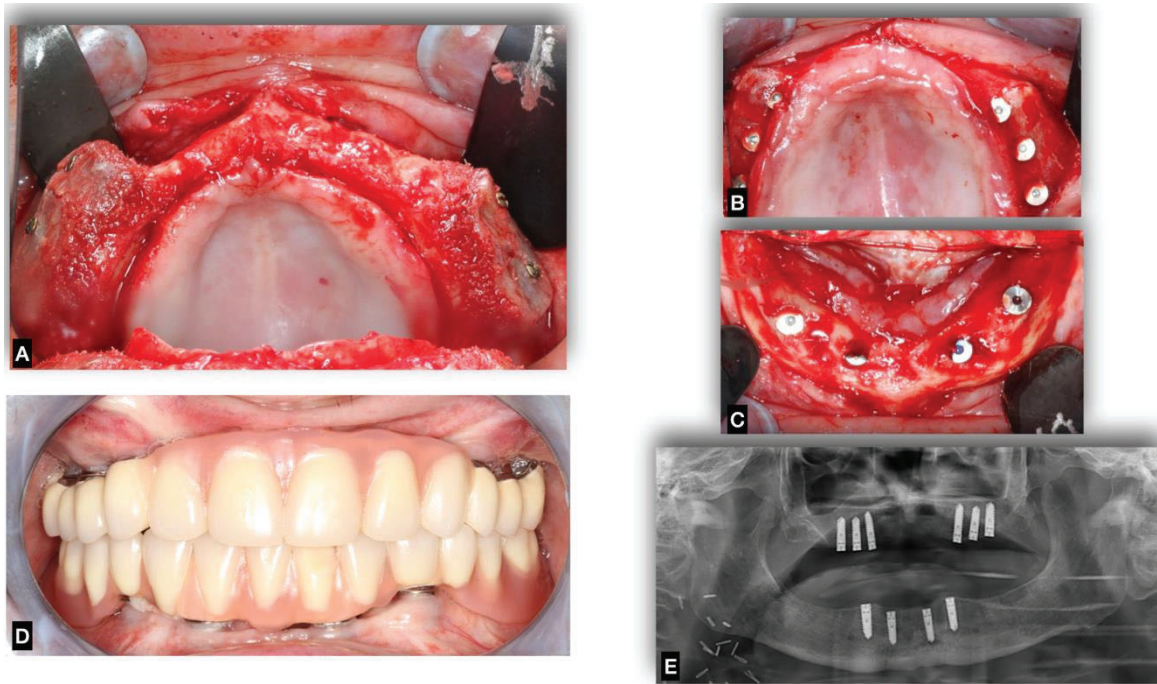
Clinical case after bone augmentation with iliac crest autograft: A) intra-operative photo showing the situation three months after the bone graft, with good healing results; B–C) intra-operative dental implant insertion, six in the maxilla and four in the mandible; D) photos after prosthetic rehabilitation; E) panoramic x-ray after implant insertion. Clinical case of the Department of Oral and Maxillofacial Surgery, University Hospital Giessen.
